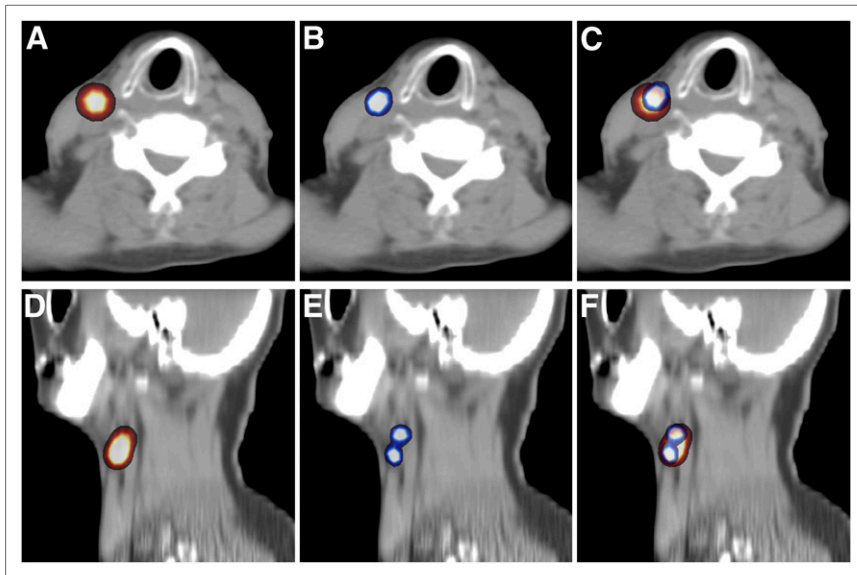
(A) SPECT/CT image of patient 1 demonstrating SN in level II of neck. (B) PET/CT image of same patient in which again SN in level II of neck was identified. (C) Fused SPECT and PET/CT image demonstrating uptake in exactly the same lymph node. (D) SPECT/CT image of patient 2, in whom 1 SN was identified (which was 2 hot spots on planar lymphoscintigraphy). (E) PET/CT image of patient 2 clearly showed 2 SNs. (F) Fused SPECT and PET/CT image again demonstrating identical drainage.
